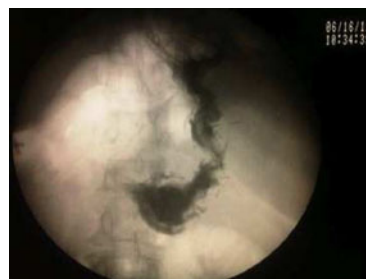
Contrasted x-ray showing stomach with sleeve-like shape
